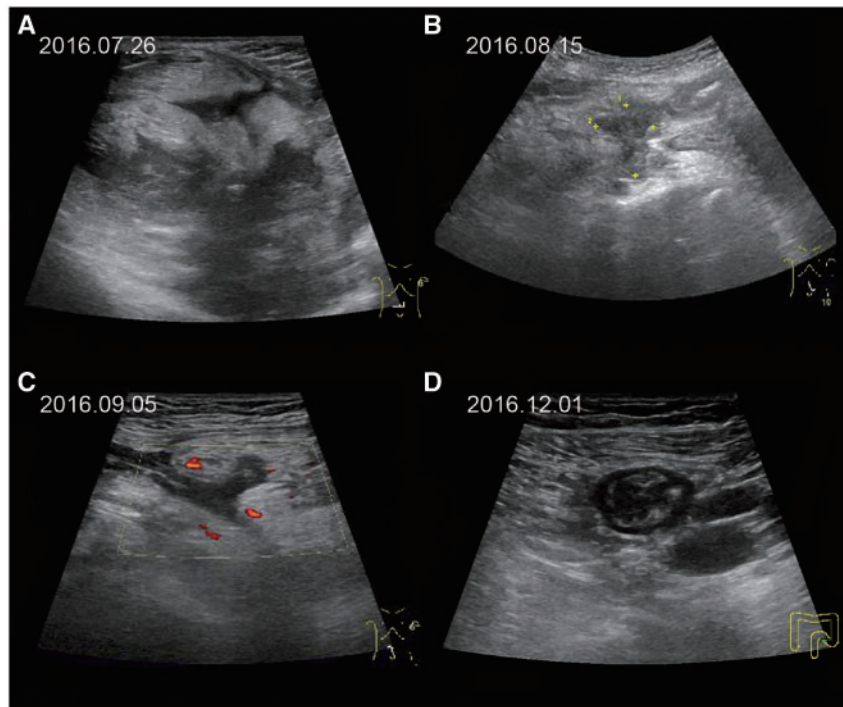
A series of bowel sonography images of a patient. (A) At baseline, there was extensive bowel-wall thickening and fistulas; abscesses and ascites are shown as a hypoecho band and liquid dark area, respectively. (B) After taking oral exclusive enteral nutrition for 20 days, abscesses and ascites were absent. (C) Significant reduction was observed in bowel-wall thickness and fistulas closed after another 20-day treatment. (D) Three months later, bowel sonography showed the maximal bowel-wall thickness was 3 mm, and no fistulas, abscesses and ascites relapsed.
